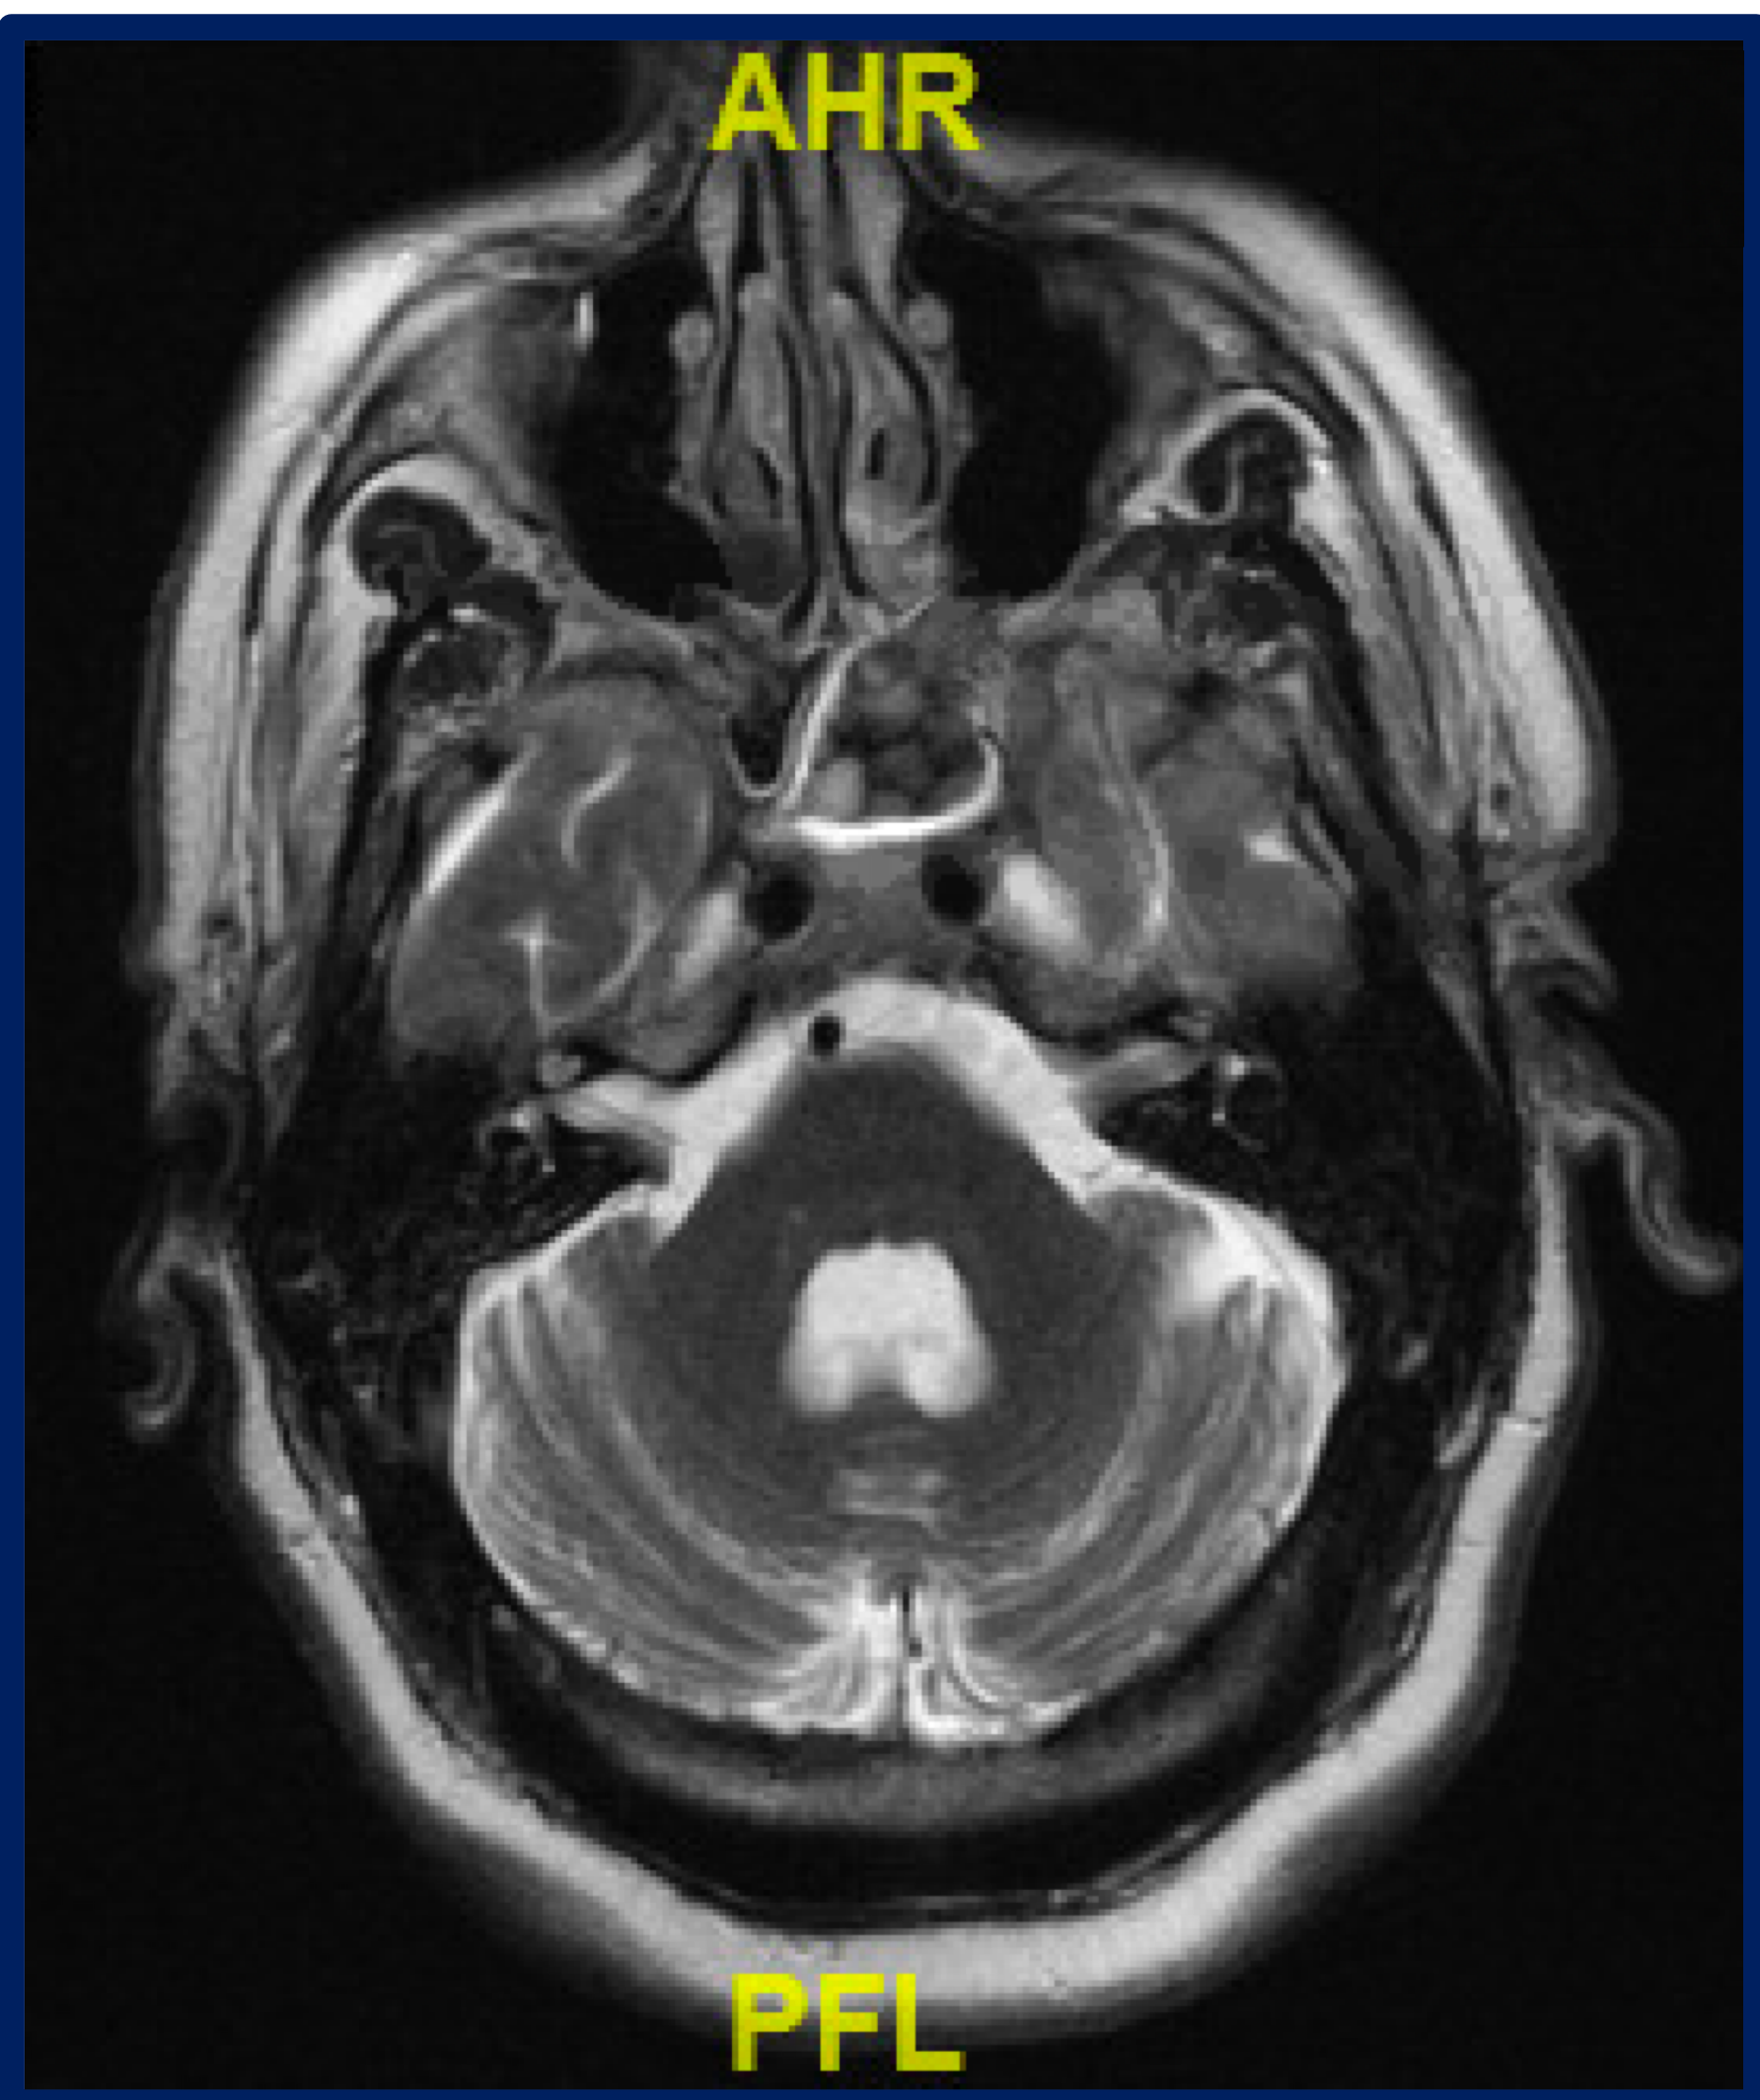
Brain MRI with hyperenhancement of bilateral facial nerves and geniculate ganglia on hospital day 2
